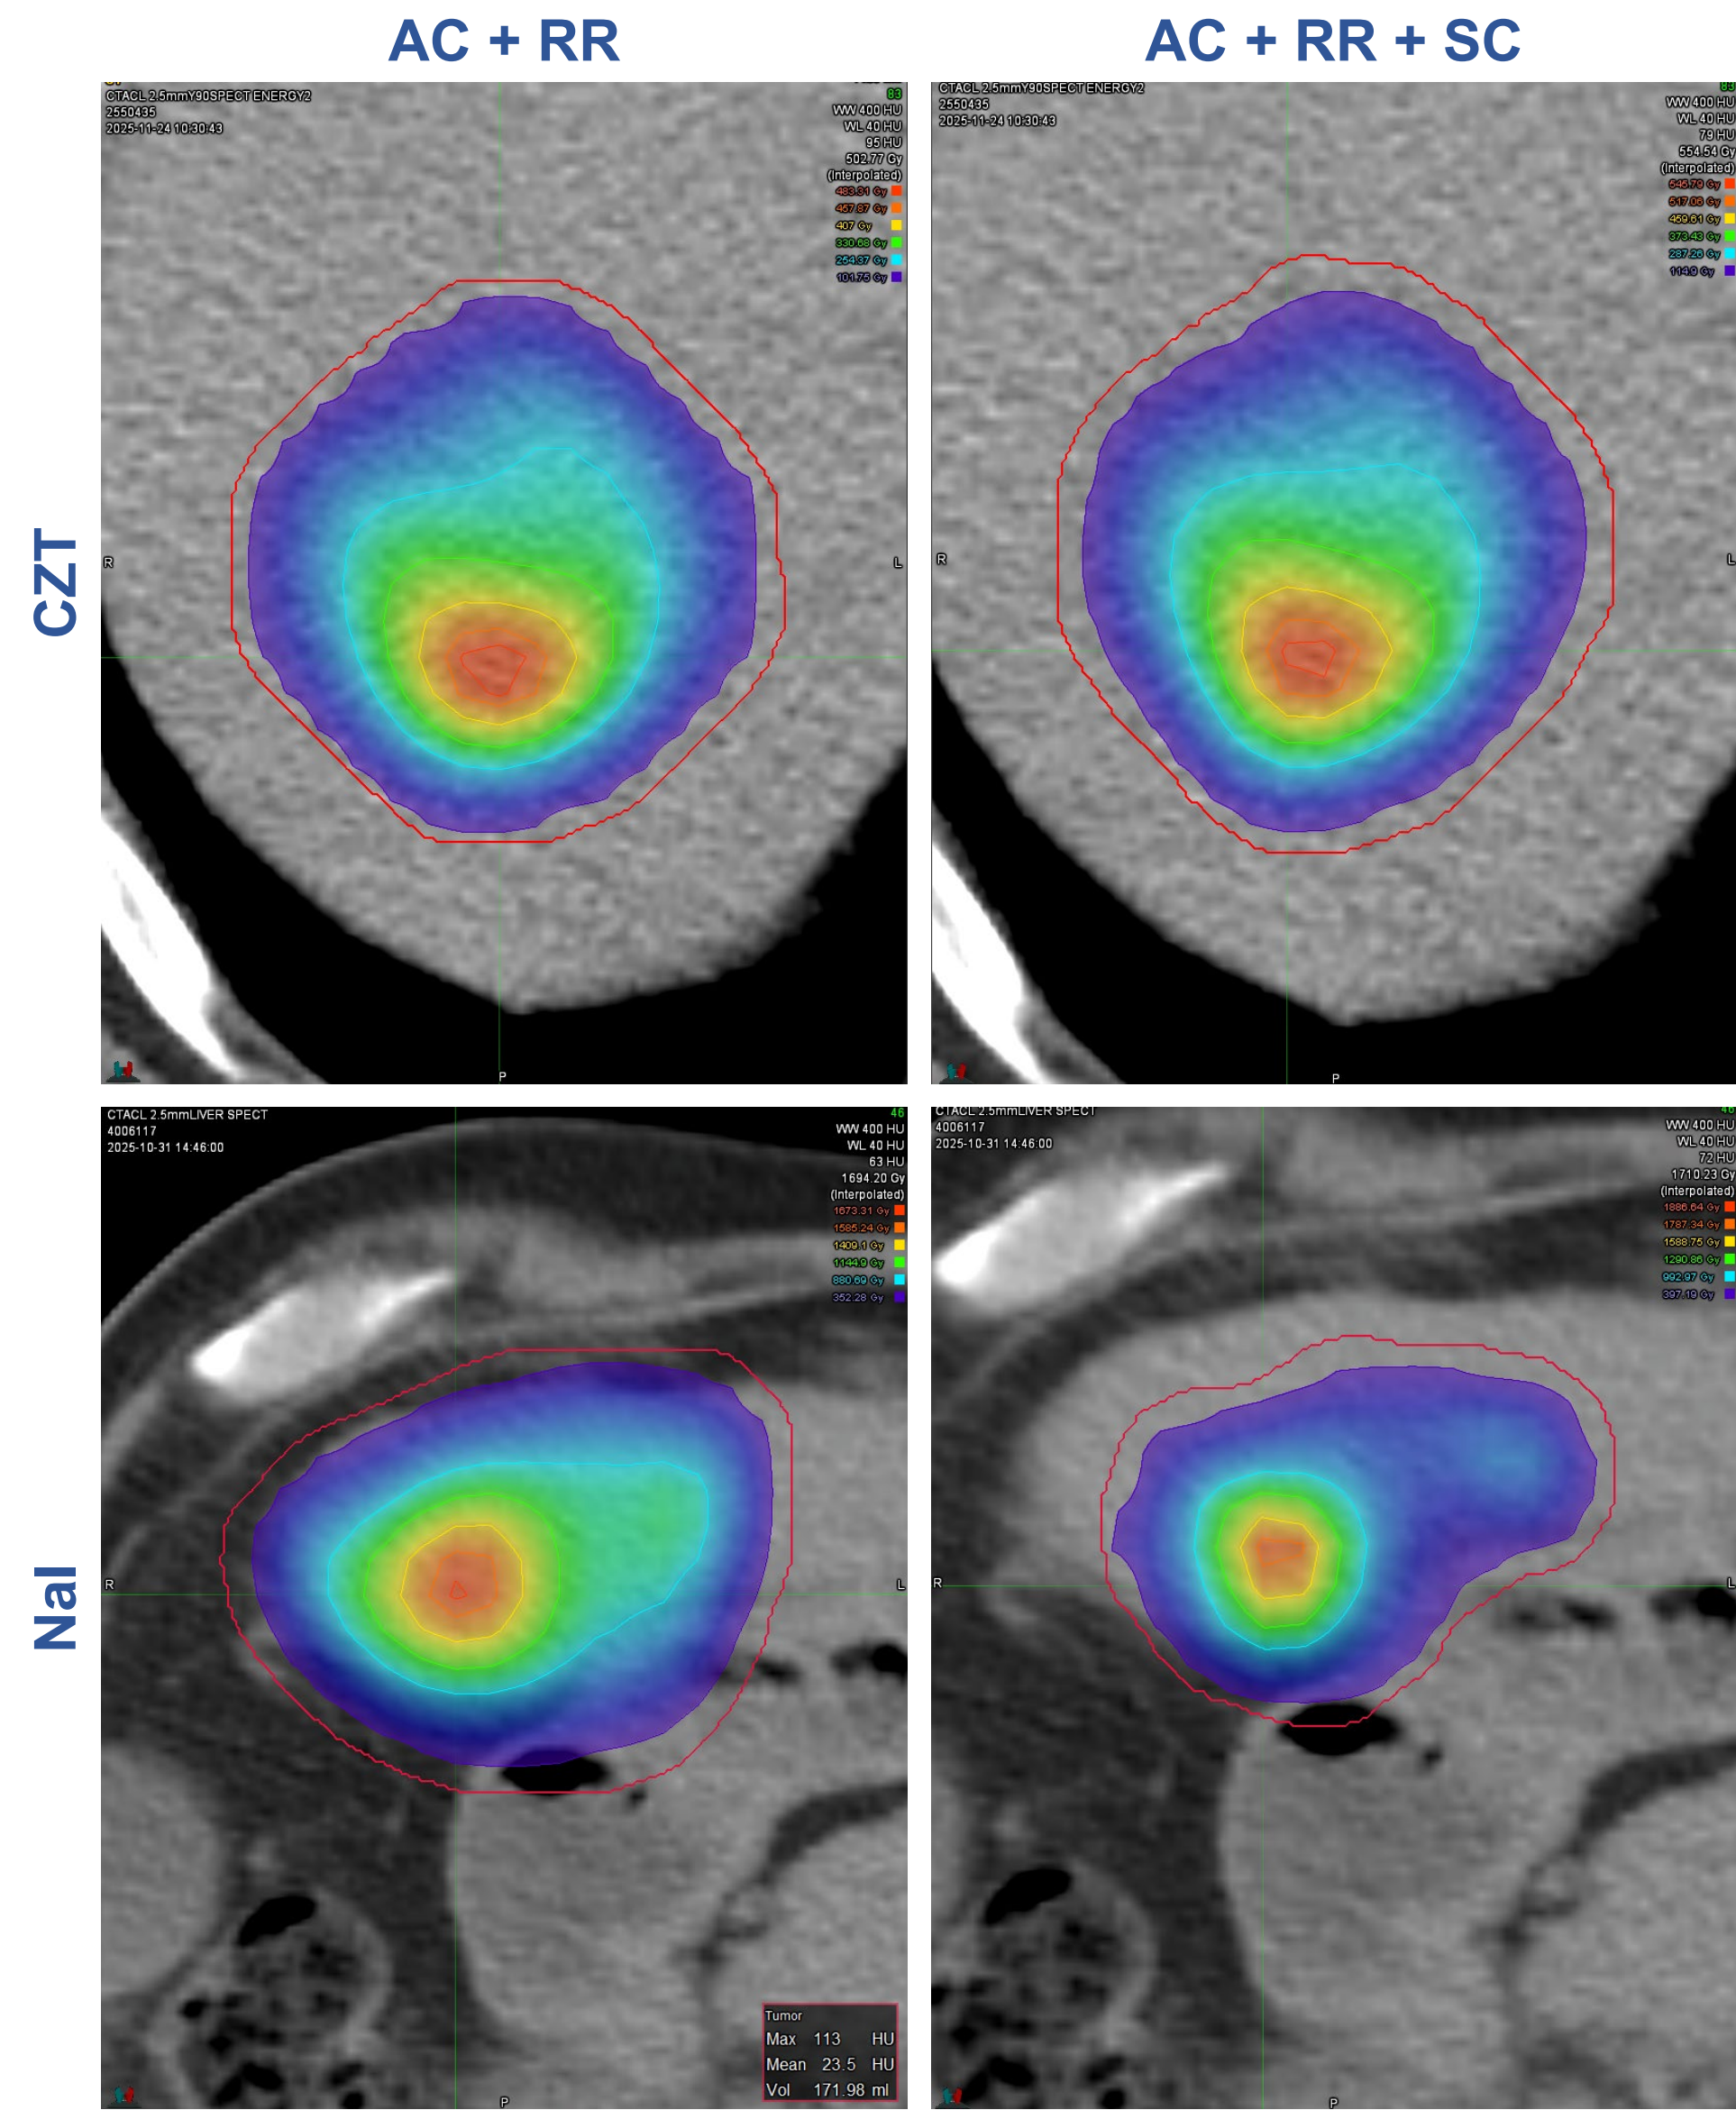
Color-rendered clinical SPECT/CT for CZT (top) and NaI (bottom): AC + RR versus AC + RR + SC. Tables summarize tumor maximum and mean absorbed dose (Gy).
